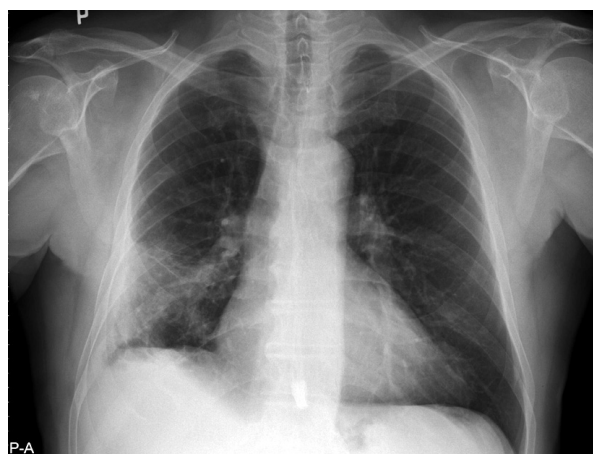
Chest radiograph showing extensive irregular patchy area of air-space consolidation in the right lower zone. The right hemidiaphragm is elevated
